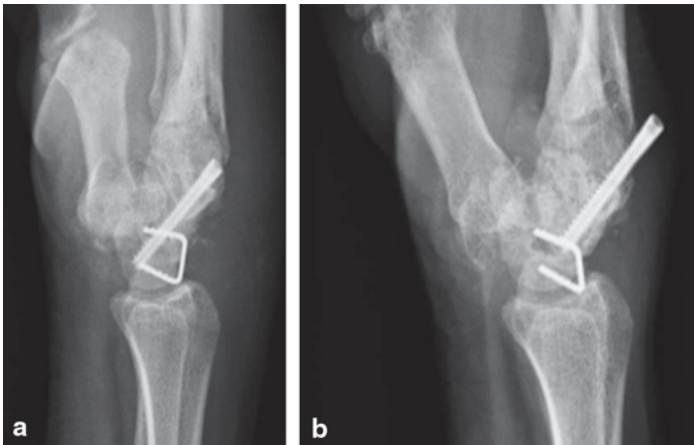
a Lateral post-op X-ray with a staple and retrograde screw placed. b Lateral X-ray demonstrating back out of the retrograde screw. (Published with kind permission of ©Glenn Gaston, 2015. All Rights Reserved)
